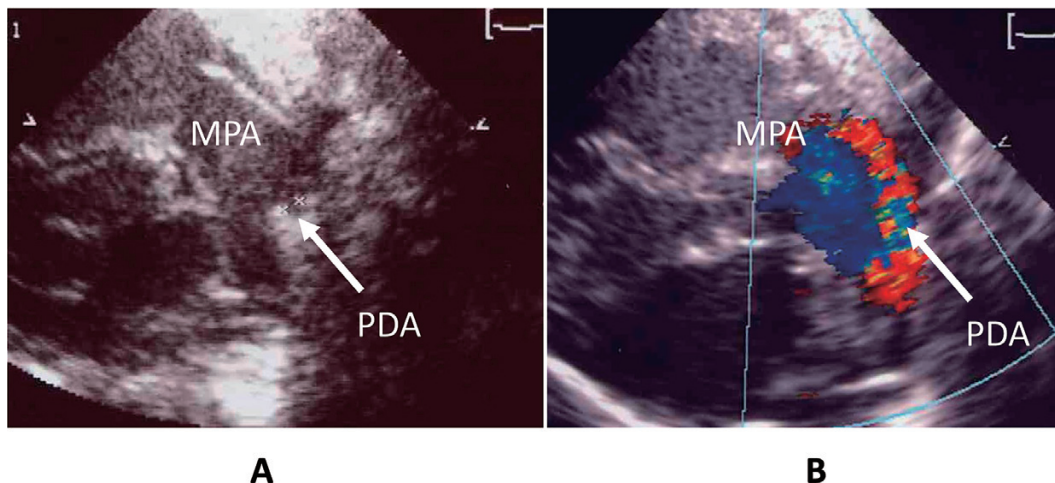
The constriction of PDA was observed at 12 days of age by echocardiography (A, B)
